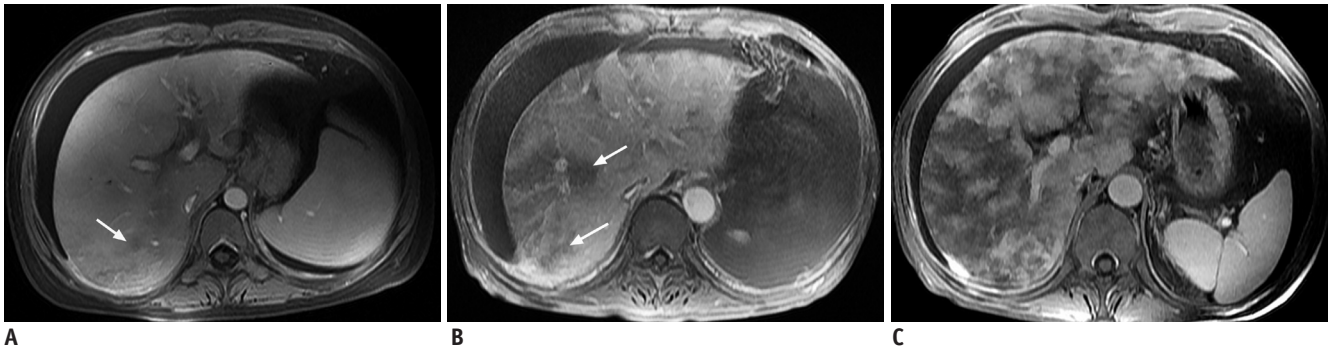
Post contrast-enhanced MR images show severity of patchy liver enhancement in hepatic sinusoidal obstruction syndrome. A. Grade 1. Arrow denotes mild patchy enhancement. B. Grade 2. Arrows denote moderate confluent patchy enhancement. C. Grade 3. Severe case with diffuse confluent patchy enhancement. Note all three cases demonstrate ascites.
